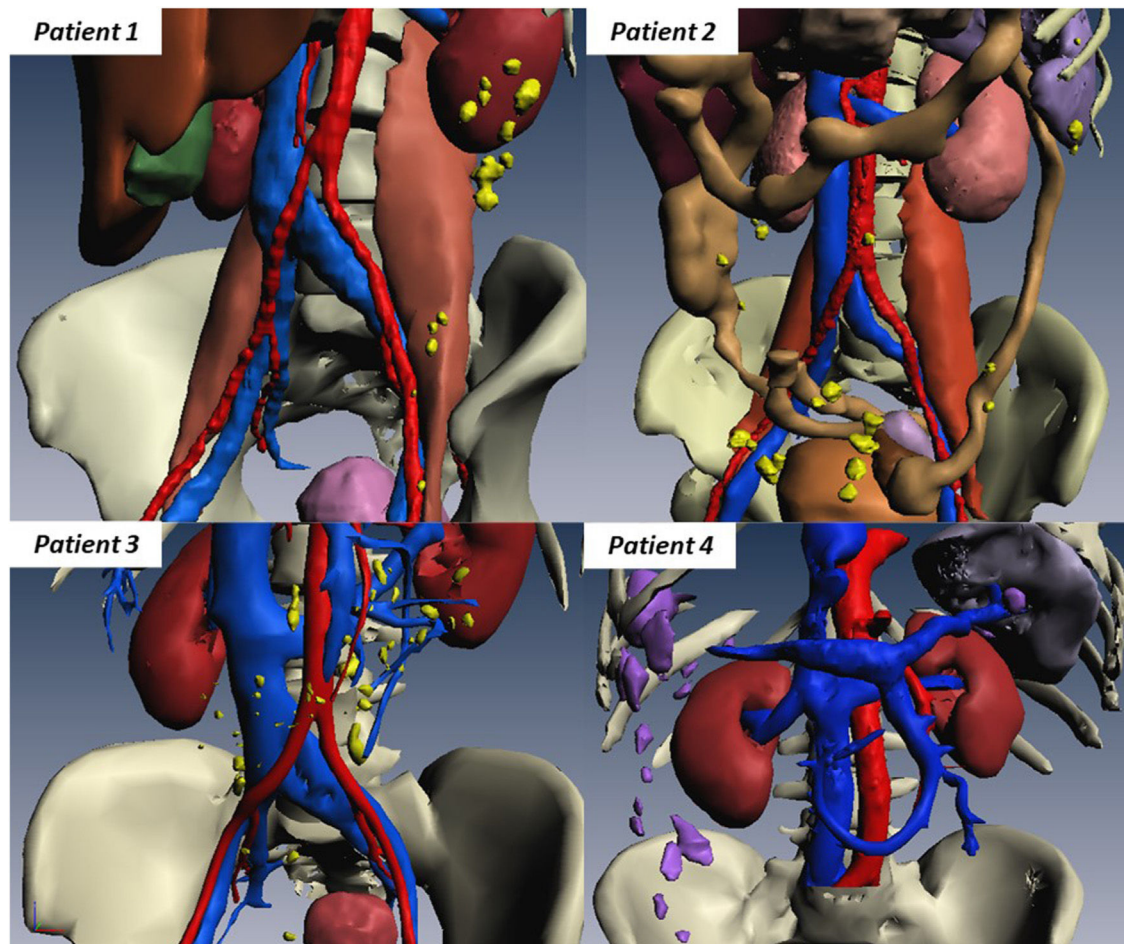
Three-dimensional reconstructions based on the preoperative CT images showing peritoneal implants (yellow in patients 1-3, purple in patient 4).
